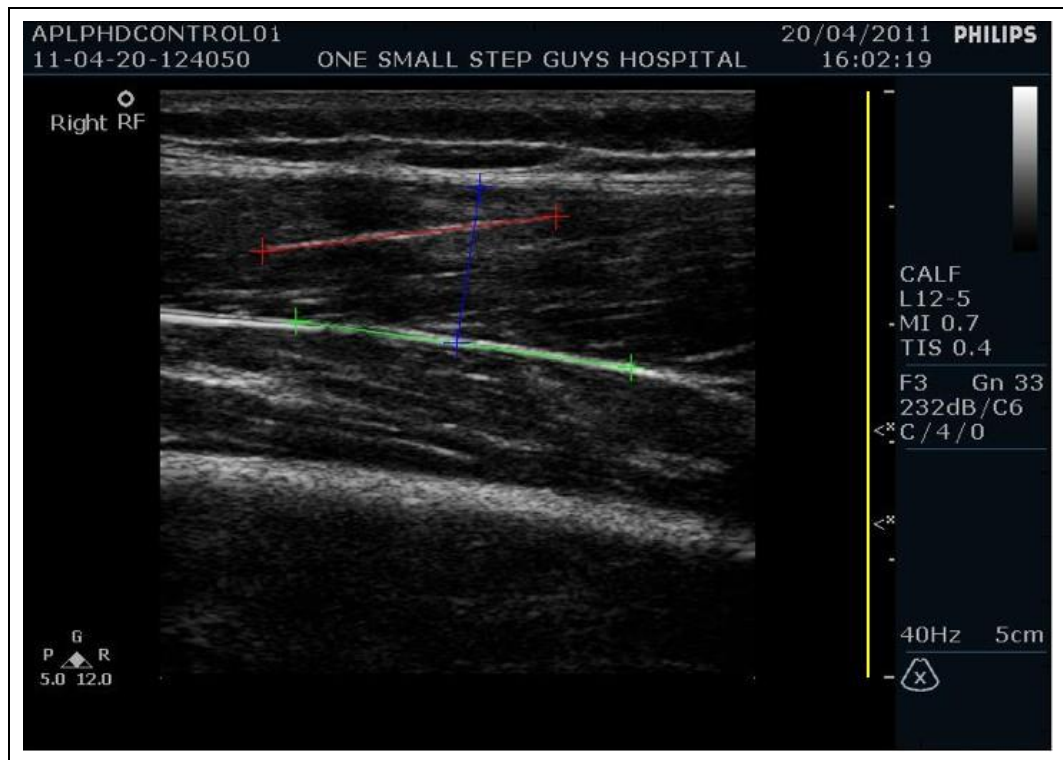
Example ultrasound image showing the rectus femoris of Control01. Four lines were drawn to allow calculation of fascicle length and pennation angle:
